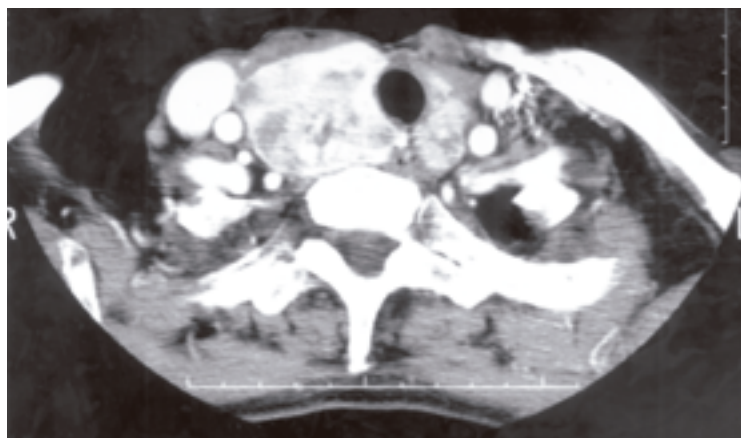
Enhanced axial CT image of the lower neck.
